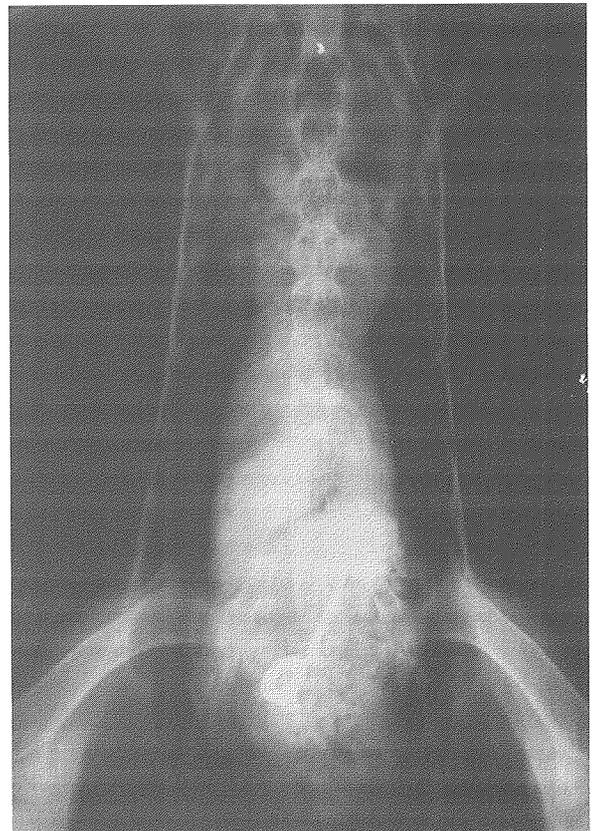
Ventrodorsal radiograph of whooping crane with ingested hardware (screw and washer) in the ventriculus. The items were free within the lumen of the ventriculus and were retrieved with an endoscope.
